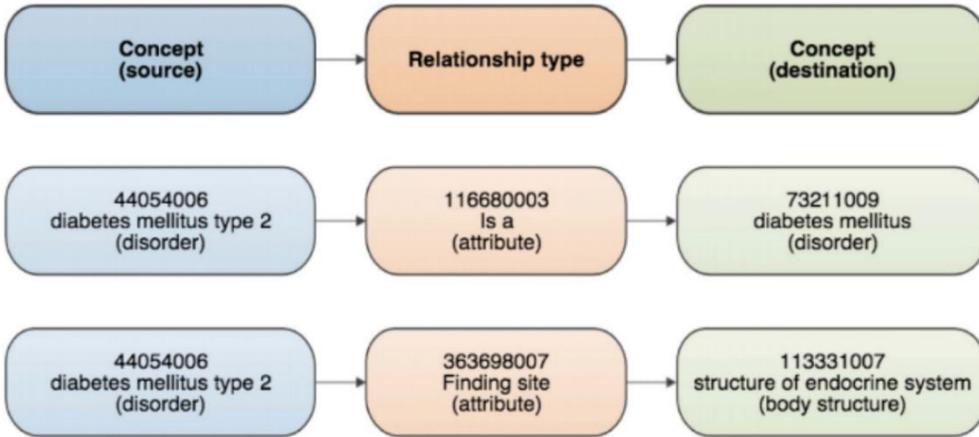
Relationships in Snomed CT ([https://confluence.ihtsdotools.org/display/DOC-START/5.SNOMED CT Logical Model](https://confluence.ihtsdotools.org/display/DOC-START/5.SNOMED+CT+Logical+Model))
